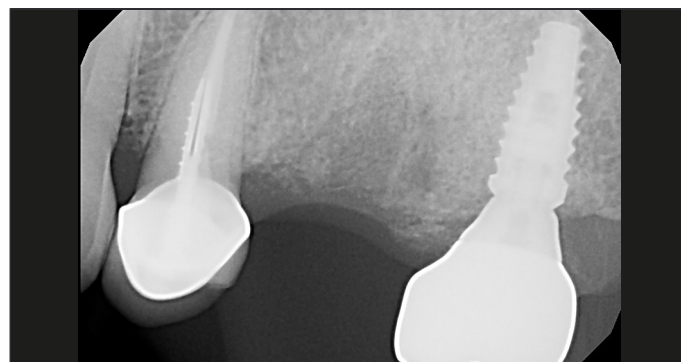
X-ray image after 1 month.
